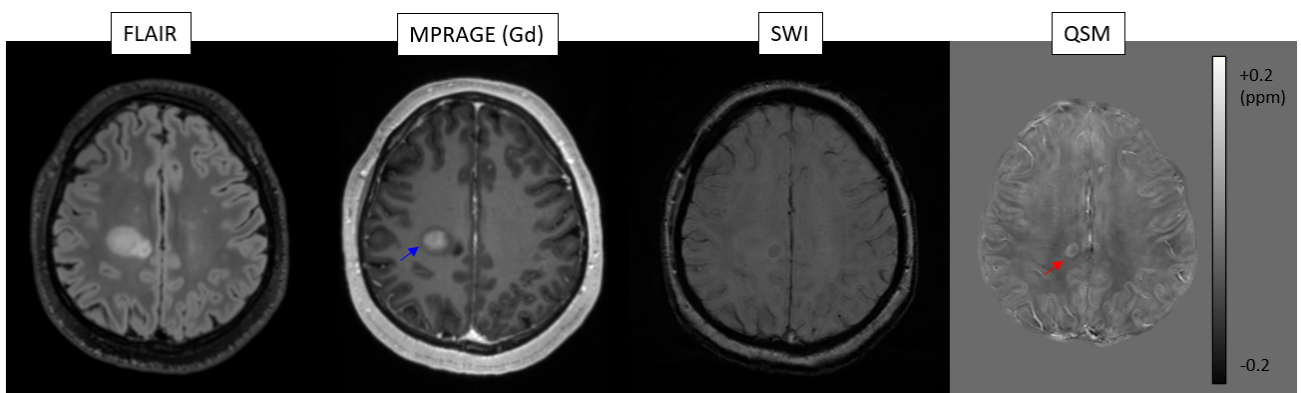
FLAIR, MPRAGE-Gd (gadolinium-enhanced), SWI and QSM in a patient with relapsing-remitting MS (F/33 years old, IRCCS Istituto delle Scienze Neurologiche di Bologna, Functional and Molecular Neuroimaging Unit). QSM allows the detection *chronic active* lesions (red arrow) reflecting an ongoing inflammatory process not Gd-enhanced - note that the lesion gains contrast in SWI image but without the rim. Instead, enhanced-Gd lesions (blue arrow) are not detectable in QSM. QSM provides quantitative measurements, thus its color bar is shown, while MPRAGE and SWI are in arbitrary units. Details acquisition parameters are in Section 1.2.1 (Tab. 1.1)
